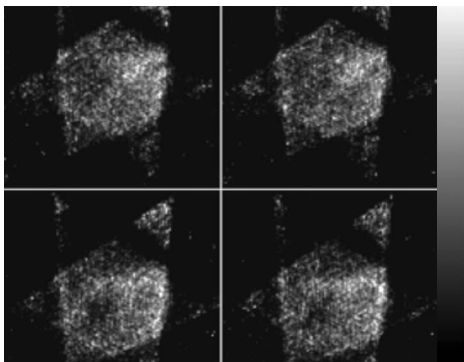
Sample R4SSH SPECT reconstructed transaxial slices (without post-filtering) of the second patient study, which failed to center the heart in the CVOV due to the patient size.
